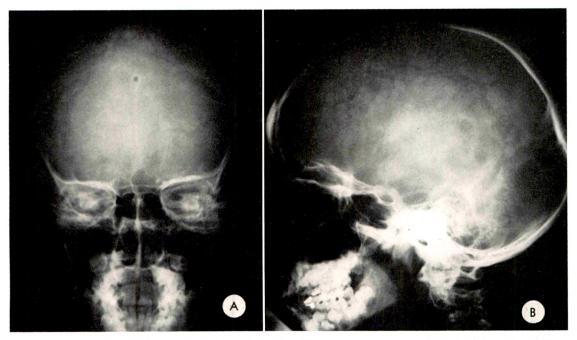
Case III. (A and B) Dandy-Walker malformation. These roentgenograms of the skull show no evidence of increased intracranial pressure, but there is elevation of the transverse dural sinuses. Note the foramen in the midline of the occipital bone which is connected to a dermal sinus.
